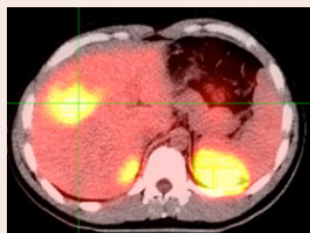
Im 68Gallium-PSMA-PET-CT Darstellung der größten Lebermetastase sowie beidseitiger Nierenanschnitte
